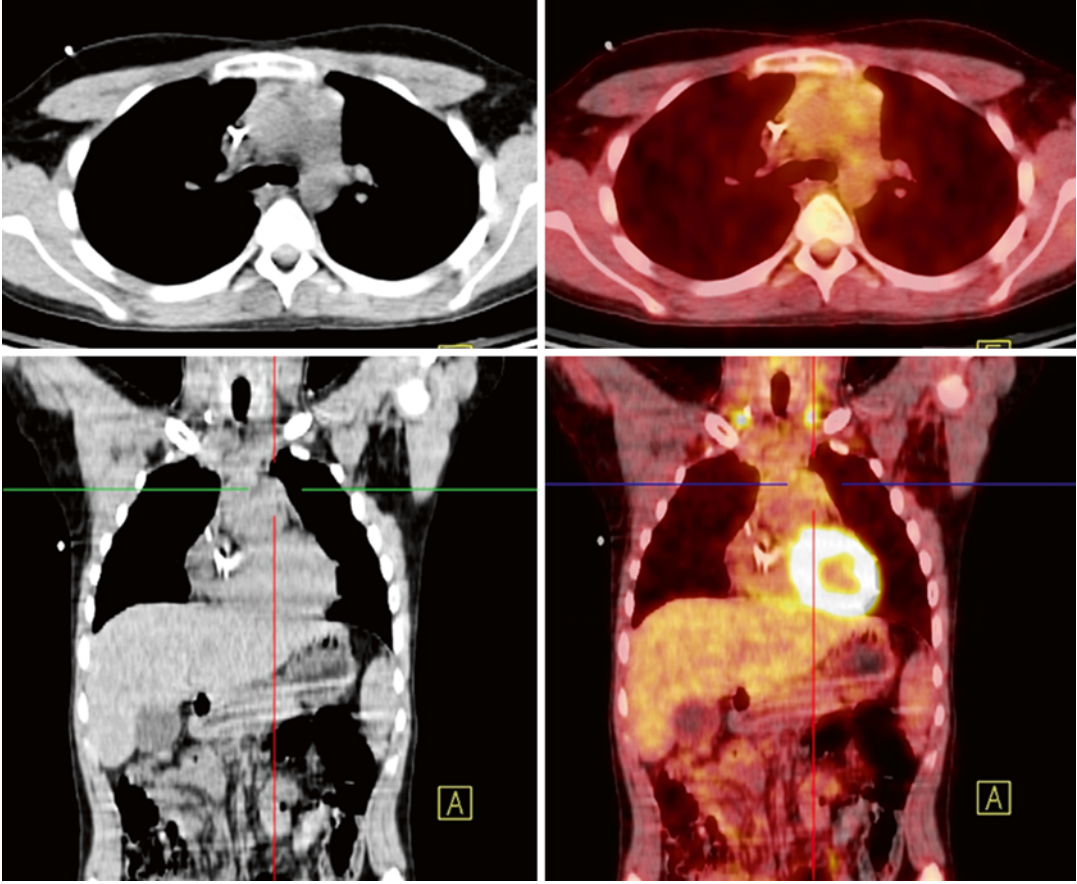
CT and fused PET/CT: Residual, mildly hypermetabolic mass at the upper mediastinum (SUVmax of 2.8)
